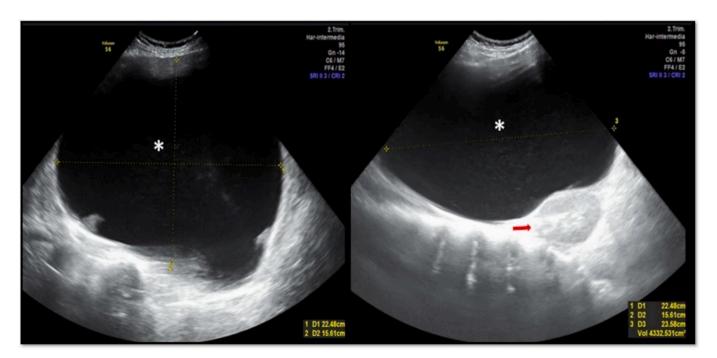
Ultrasound image of the retroperitoneal lymphangioma: anechoic retroperitoneal tumor of regular contours, $224 \times 156 \times 235$ mm in size, with no uptake on Doppler ultrasound. Arrow: left kidney.
